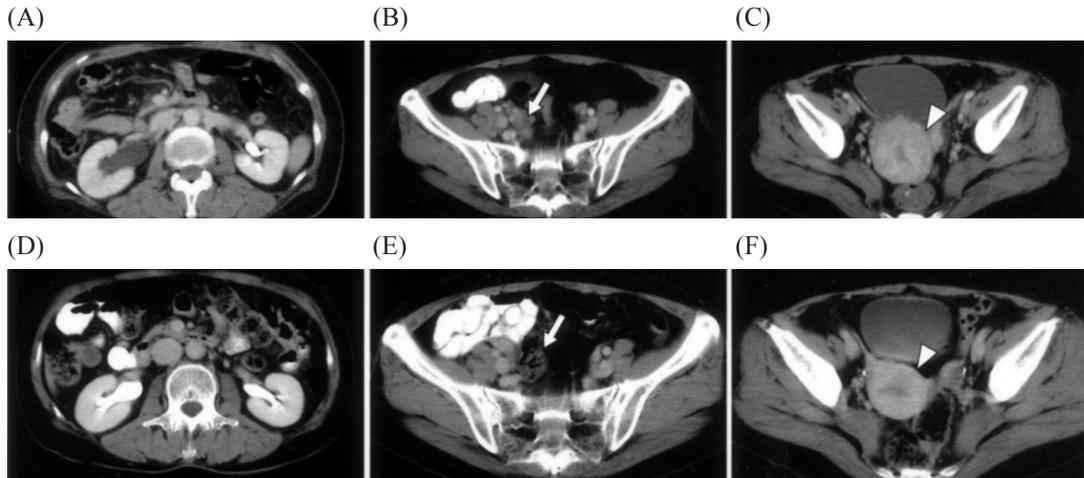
(A)-(C) Pelvic CT at diagnosis showed right hydronephrosis and hydroureter, right lower retroperitoneal lymph nodes (white arrow), and a uterine cervical tumor (white arrowhead) with heterogeneous enhancement, respectively. (D)-(F) After gefitinib treatment for 3 months, pelvic CT showed improvement in the right obstructive uropathy and regression of the right lower retroperitoneal lymph nodes (white arrow) and the uterine cervical tumor (white arrowhead), respectively.
